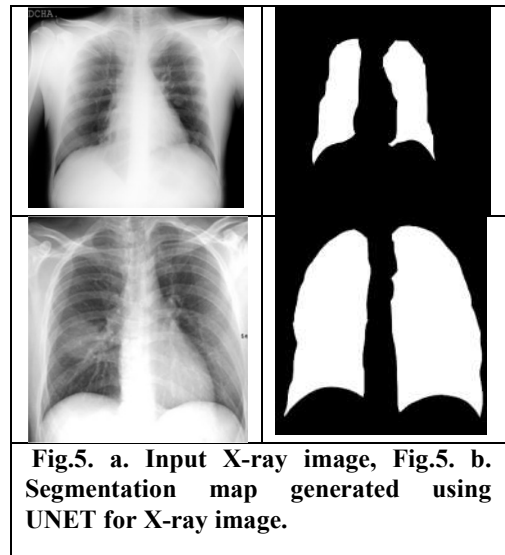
a. Input X-ray image, Fig.5. b. Segmentation map generated using UNET for X-ray image.
